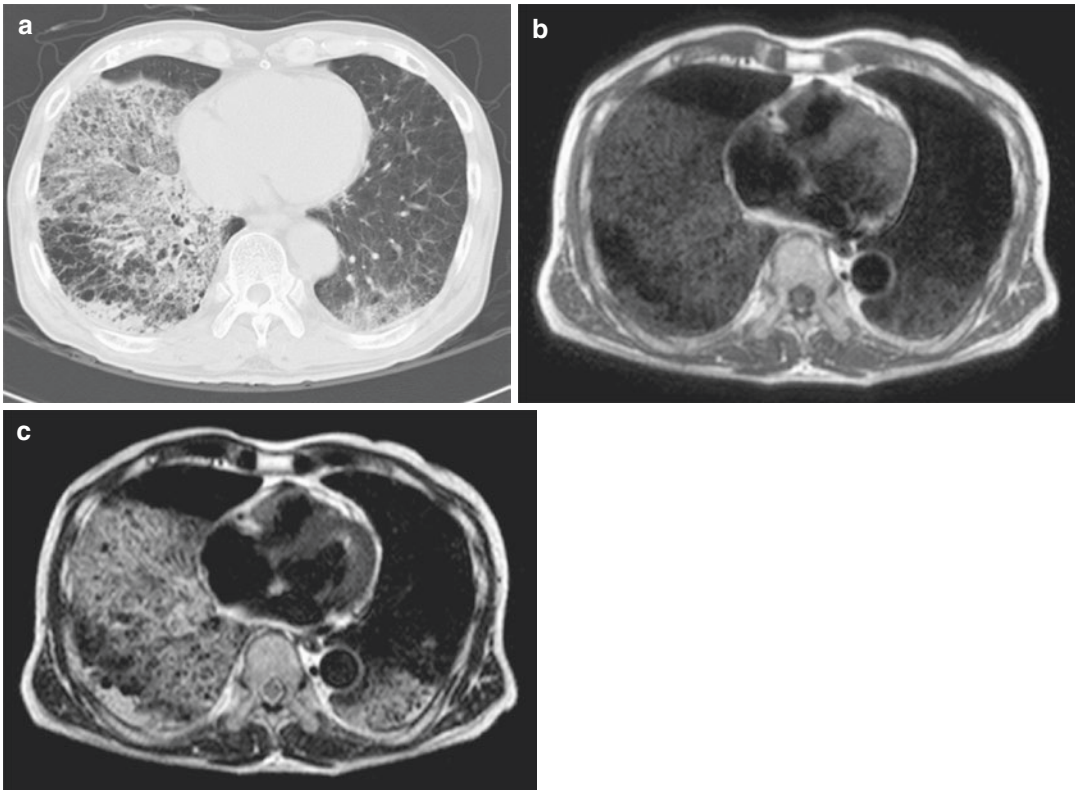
A 73-year-old male with mucinous bronchoalveolar carcinoma (BAC) in the right middle and both lower lobes. Conventional CT shows ground-glass attenuation in the right middle and both lower lobes (a). Black-blood
